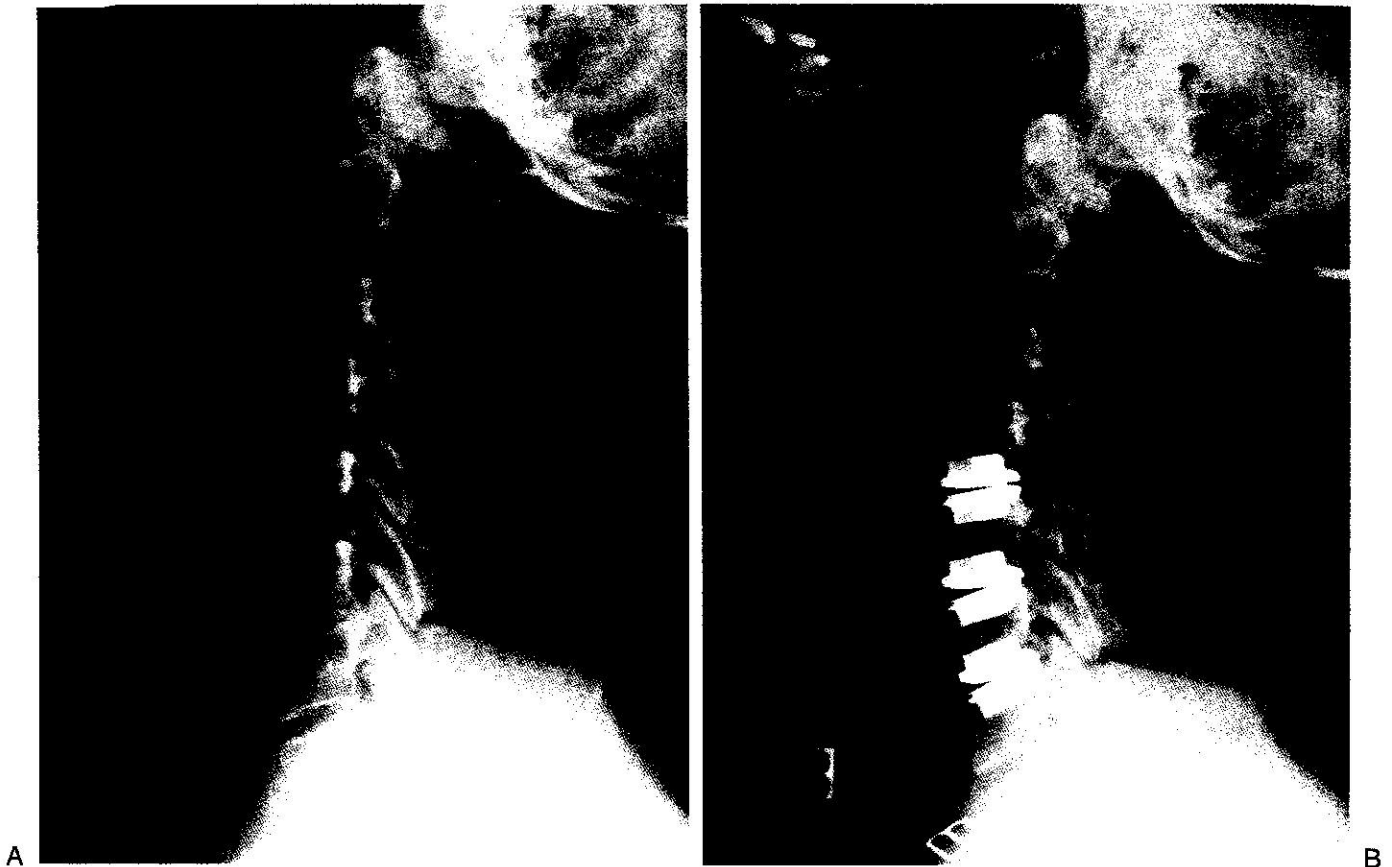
A, Preoperative lateral radiograph showing multilevel cervical disc degeneration. B, Postoperative lateral radiograph of the same patient after three-level cervical disc replacement.
